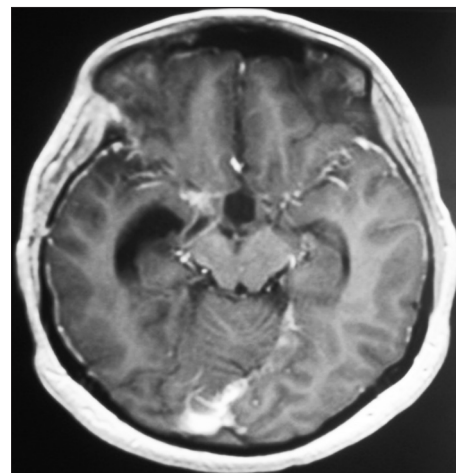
Postoperative contrast magnetic resonance imaging scan of the same patient showing complete removal
